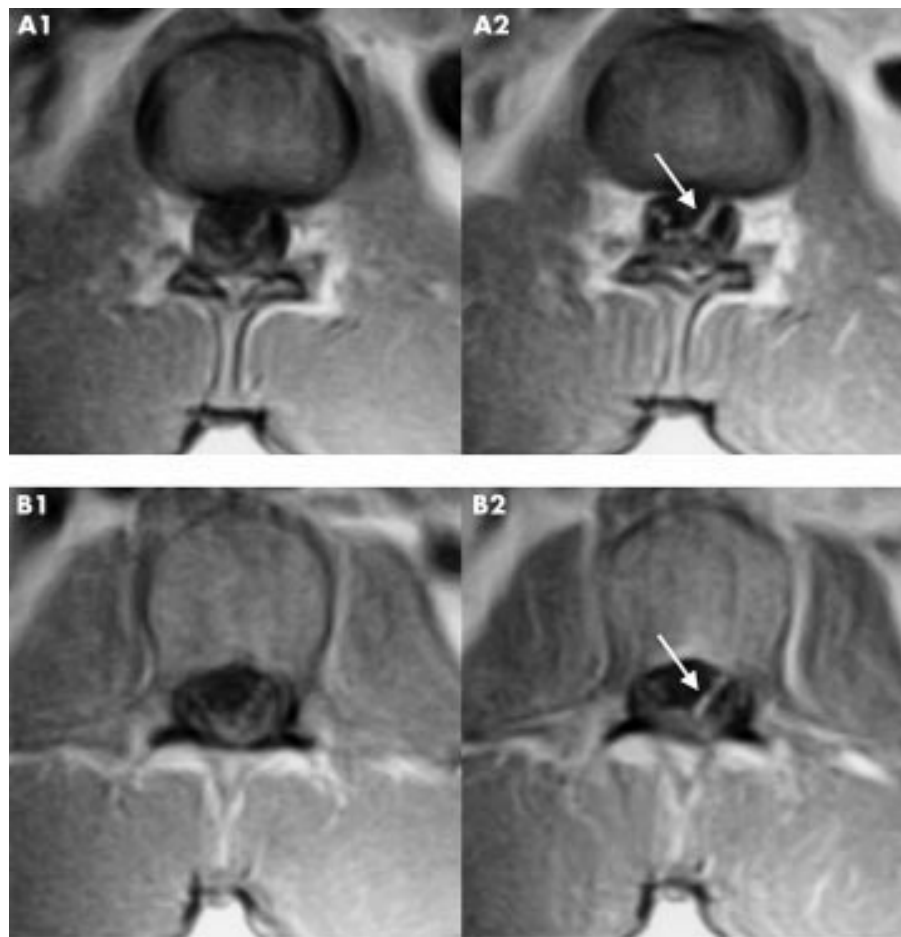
Magnetic resonance imaging of T1 weighted pre- (A1, B1) and post- (A2, B2) gadolinium axial sections of the lumbar cord. Levels L1-2 (A1, A2) and L2-3 (B1, B2) are pictured, showing greater enhancement of nerve roots on the left (arrows).
